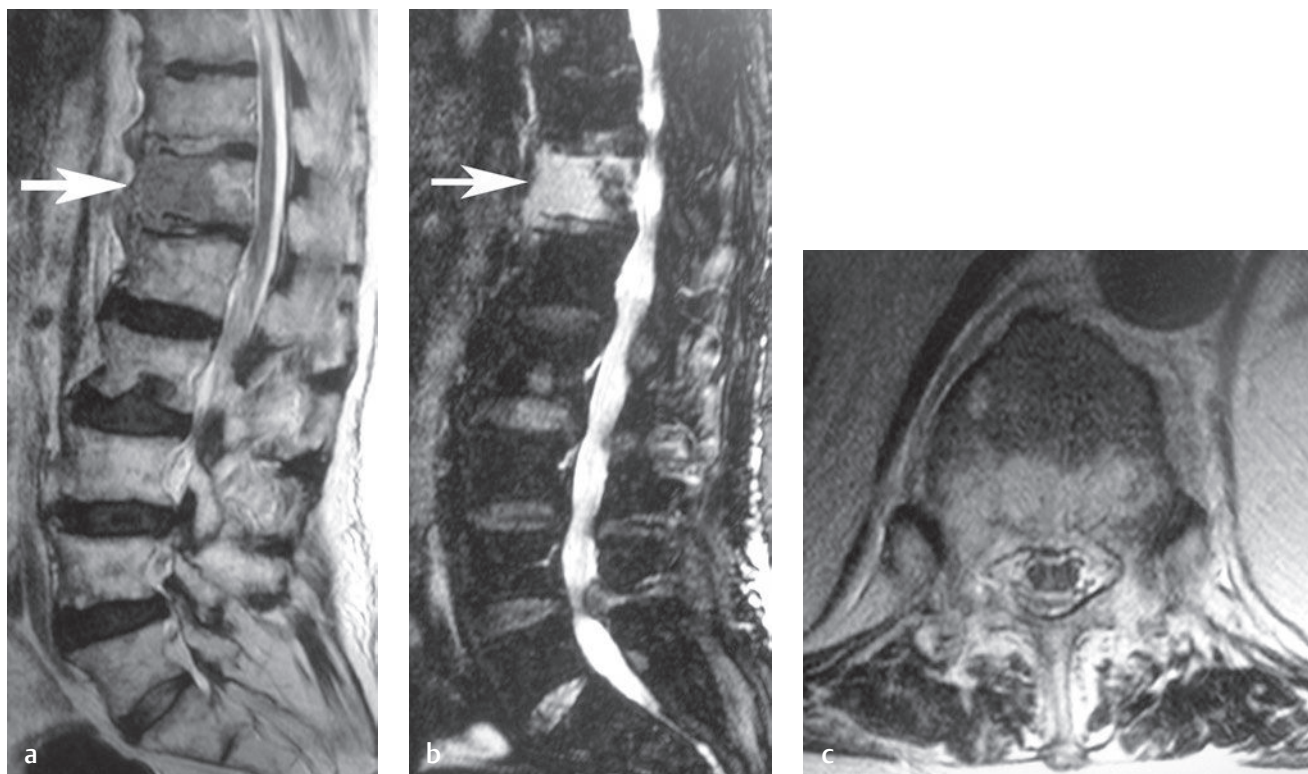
Vertebral body metastasis in a patient with lung cancer. (a) A sagittal T2-weighted image shows heterogeneous bone-marrow signal intensity in multiple vertebral bodies (which can be seen with osteoporosis) but most prominently within the anterior half of the T12 vertebral body (*arrow*). Note that the anterior aspect of the vertebral body appears expanded as it is infiltrated with tumor. (b) A sagittal STIR image shows markedly increased signal intensity in the same region (*arrow*). (c) An axial T2-weighted image shows heterogeneous signal intensity within the vertebral body. A percutaneous biopsy confirmed evidence of metastatic lung cancer.[†]
